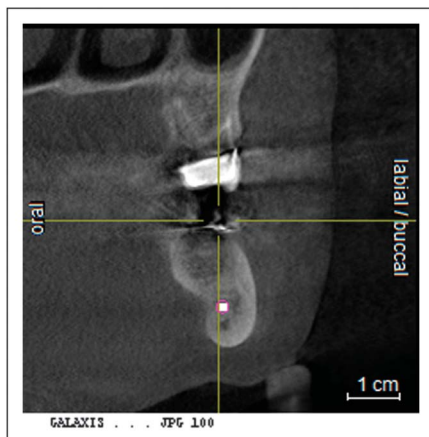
Subject 1: CBCT sagittal cross section in the area of the mandibular second molar 6 months post grafting. Note the buccal lingual ridge thickness.
